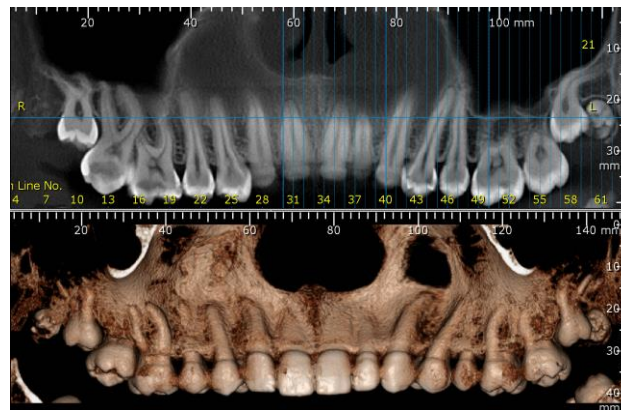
CBCT : maxillary 3D and panoramic view
